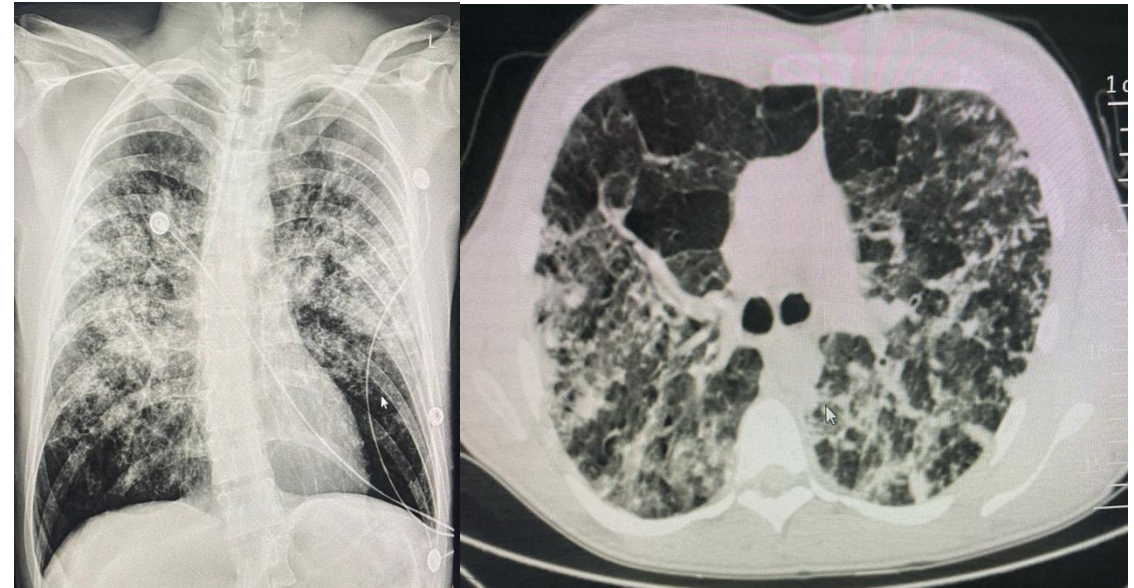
Chest CT of Patients with COVID-19 Infection
